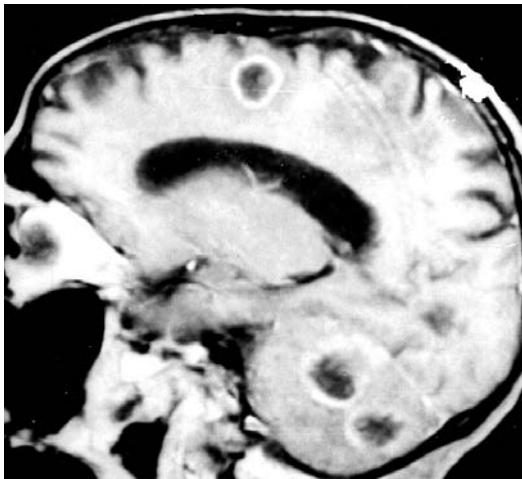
Post contrast MRI in sagittal plane showing multiple tubercular lesions in frontal lobe, occipital lobe and cerebellum
